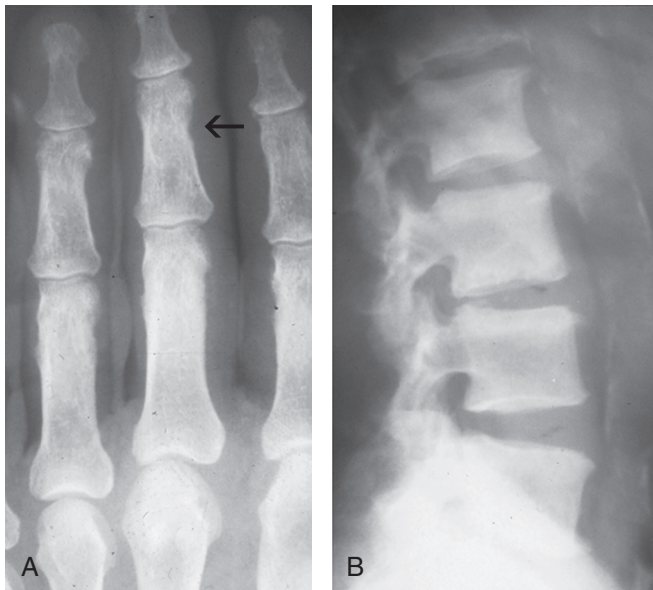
Radiographs in renal osteodystrophy. A, Subperiosteal resorption of the middle phalanx (arrow). B, Focal paradoxical sclerosis manifested by vertebral end plate density termed “ruger jersey spine.”
